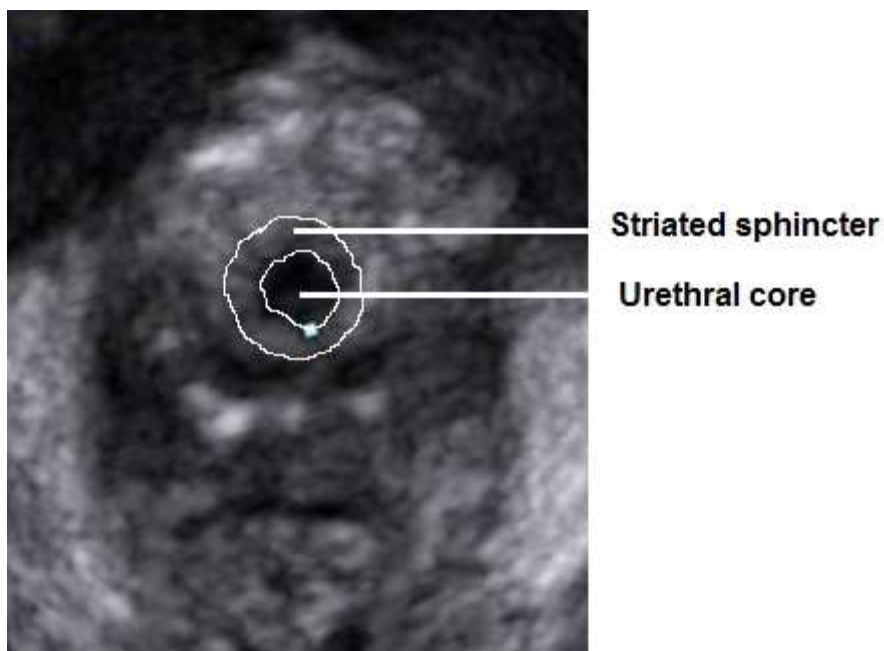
Images of the urethra by 3D transperineal ultrasound.
